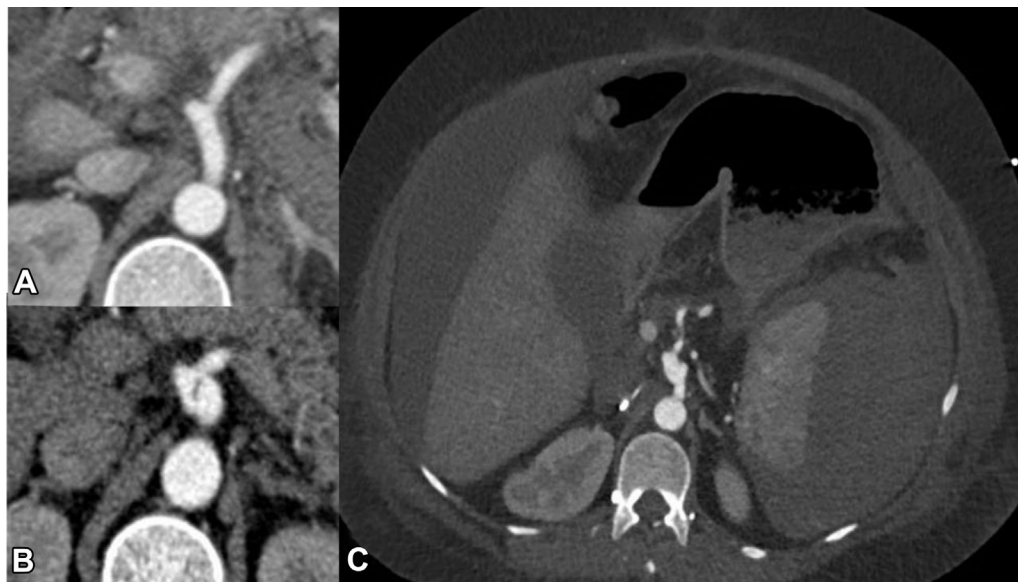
Celiac artery dissection in 36-year-old woman with vascular Ehlers-Danlos syndrome (vEDS) owing to a splice site mutation (c.2337+2T>C/p.Gly762_Lys779del) managed medically. A, Axial computed tomography imaging obtained 1 month before the dissection when she presented with a spontaneous hemoperitoneum managed medically. B, Axial computed tomography imaging demonstrating focal dissection and mild enlargement of the celiac artery. This remained unchanged on follow-up imaging over the next 5 years. C, Axial imaging demonstrating a large spontaneous subcapsular splenic hematoma and hemoperitoneum. This occurred after a complicated hospitalization for perforated sigmoid diverticulitis requiring sigmoid resection, transverse colostomy, and Hartmann's pouch.
